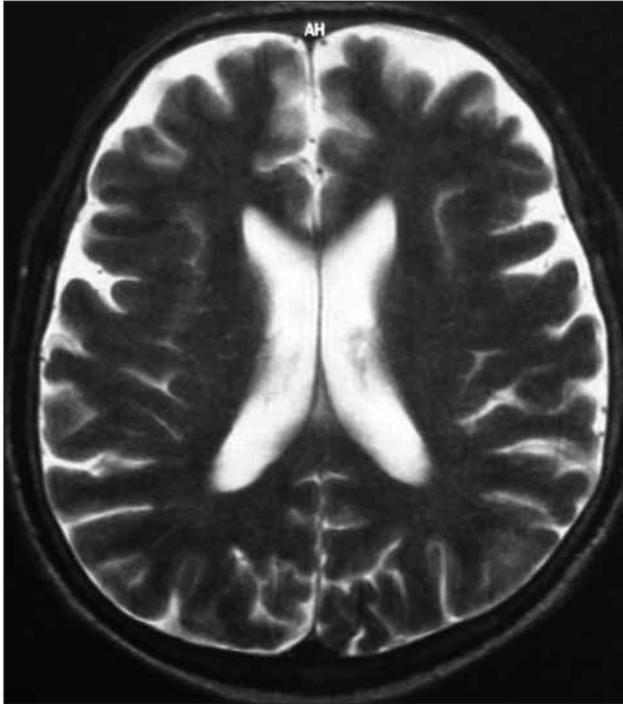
Postoperative axial MRI of brain showing no apparent brain edema or additional pathology four weeks after bilateral jugular venous system ligation.
